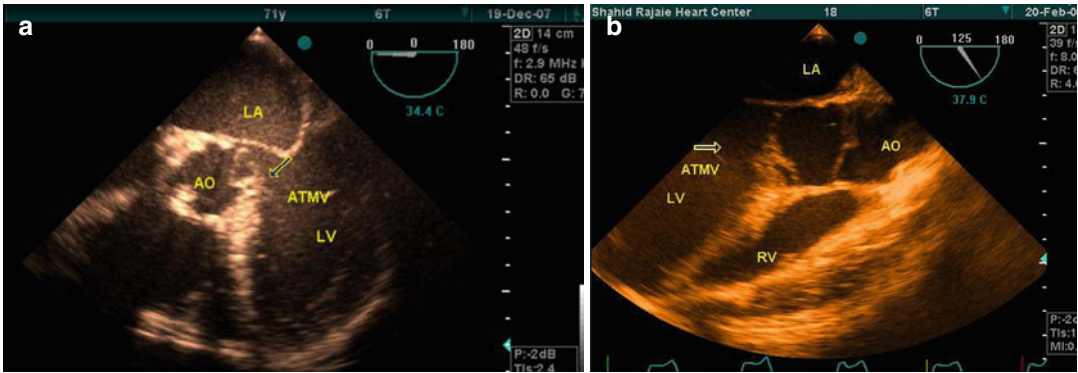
(a, b) Showing accessory tissue mitral valve (ATMV) in transesophageal echocardiography long-axis view. *ATMV* accessory tissue mitral valve, *LA* left atrium, *LV* left ventricle, *AO* aorta
